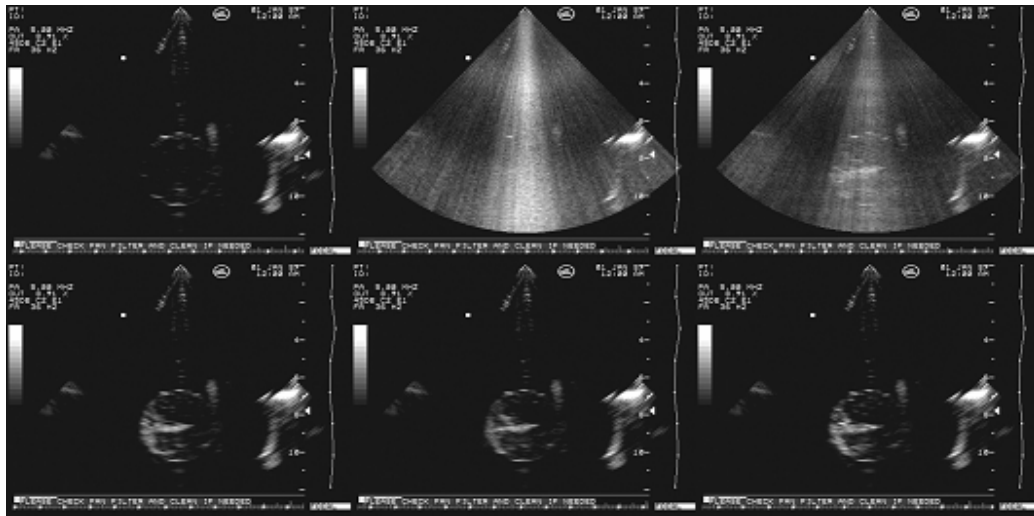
PLA microbubbles excited by an ultrasonic pulse of 750 mVpp.
